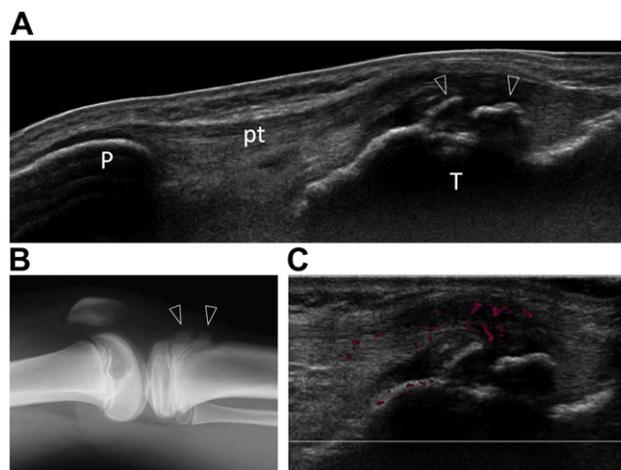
Sonography from a 10-year-old male athlete. The patient complained of a painful lump at his anterior knee. The clinical diagnosis was Osgood–Schlatter syndrome. (A) Sonographic appearance of anterior knee shows patellar tendon (pt) inserting to tibia (T) and patella (P). Note the irregular margin of the tibial insertion (open arrowheads) compared to that of the smooth margin at patellar insertion. (B) Lateral view of roentgenogram of his knee shows identical bony irregularity (open arrowheads) at tibia. (C) Power Doppler ultrasonography depicts increased blood flow in the affected tendon.
